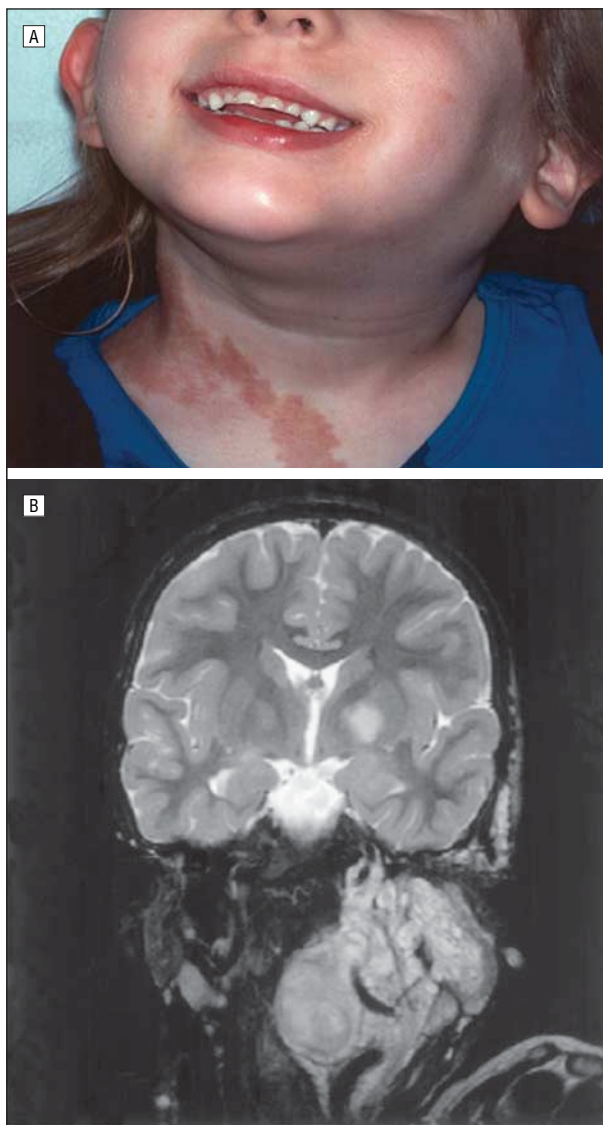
Patient 3, a 7-year-old girl, had a large, left-sided neck mass. A, Color photograph clearly shows the café au lait spots on her right neck; B, T2-weighted magnetic resonance image in the coronal plane demonstrates a massive enhancing vagal plexiform mass within the carotid sheath space with extension to the skull base. The ipsilateral carotid artery is patent but displaced anteriorly.
